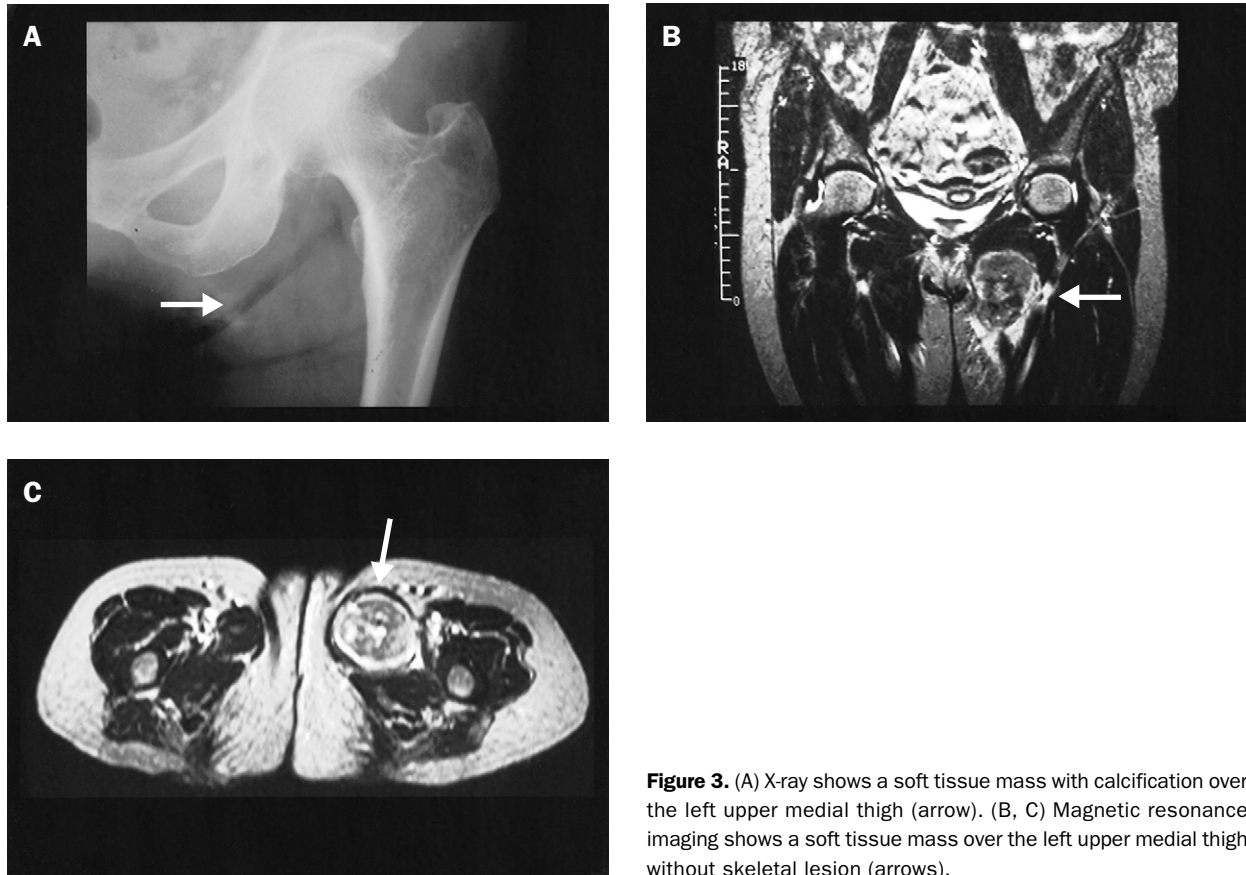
(A) X-ray shows a soft tissue mass with calcification over the left upper medial thigh (arrow). (B, C) Magnetic resonance imaging shows a soft tissue mass over the left upper medial thigh without skeletal lesion (arrows).
